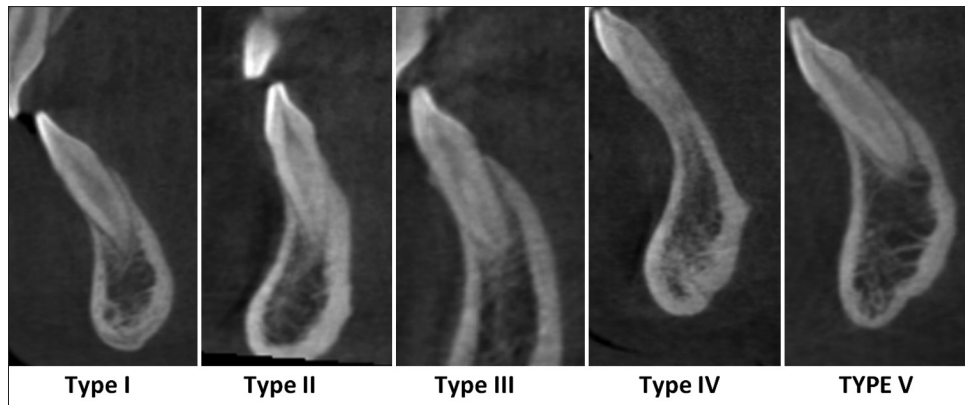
CBCT images showing the five variants in permanent mandibular incisors according to the Vertucci's classification
